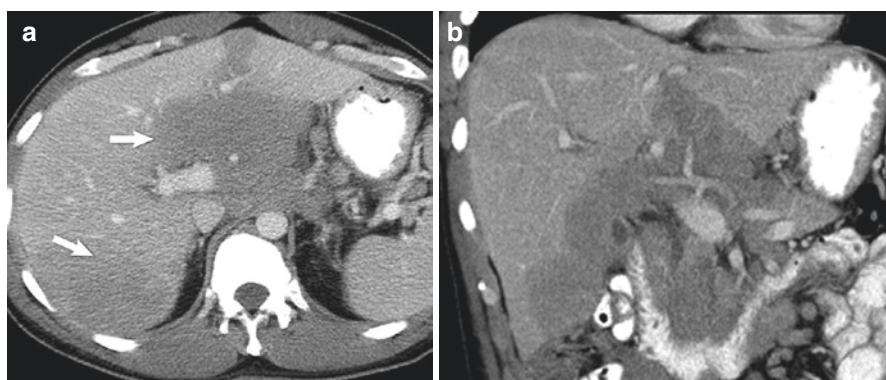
A 50-year-old man status post liver transplant with infiltrative liver PTLD. (a) Contrast-enhanced CT shows multifocal geographic areas of low attenuation in the liver (arrows). (b) Coronal image shows a portal vein coursing through the tumor without narrowing or occlusion
